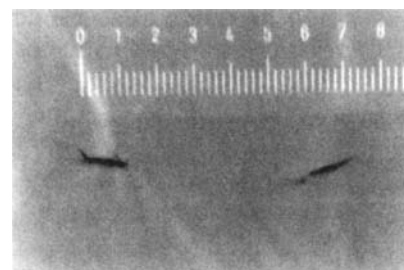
Radiograph of lead apron with cracks. Scale in centimeters.
